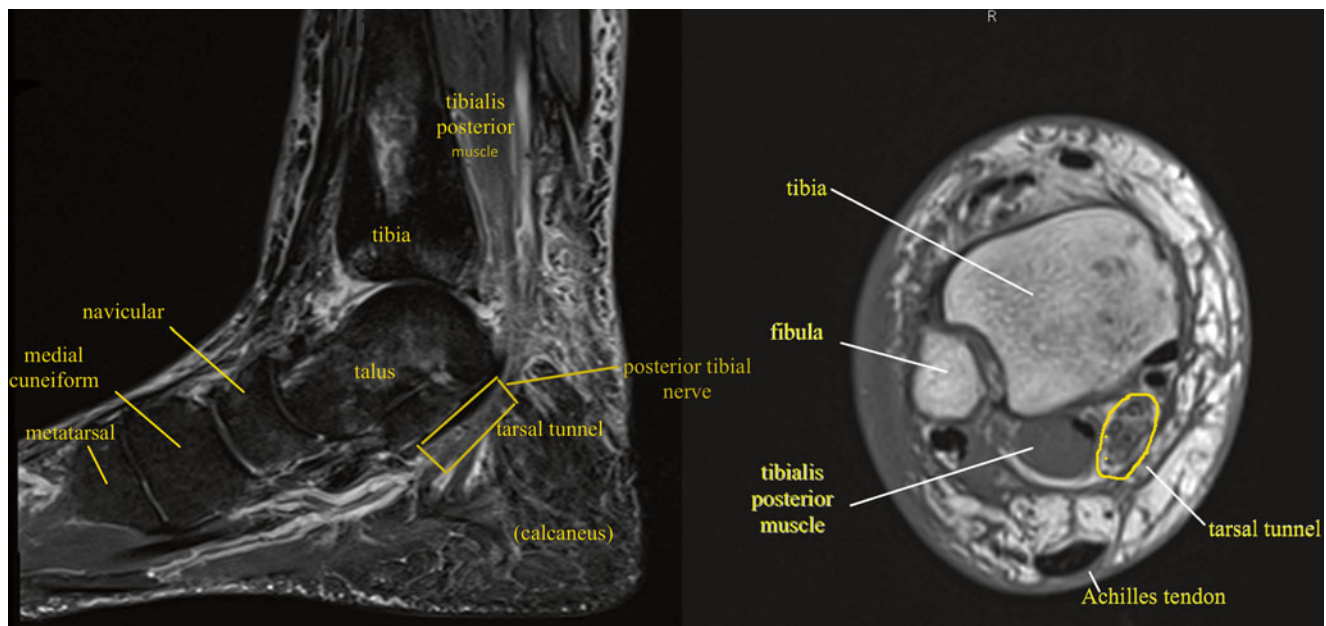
MRI (sagittal and axial) of the tarsal tunnel (Image courtesy of Andrea Trescot, MD)
